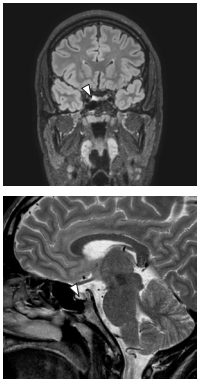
T2 weighted MRI - oval area of T2 hyper-signal (closed arrow), with approximately 8 mm, on the anterior and right lateral aspect of the adenopharynx, allied with a slight increase in volume height of the pituitary gland on that side and a slight deviation of the pituitary stalk, compatible with an adenoma.
